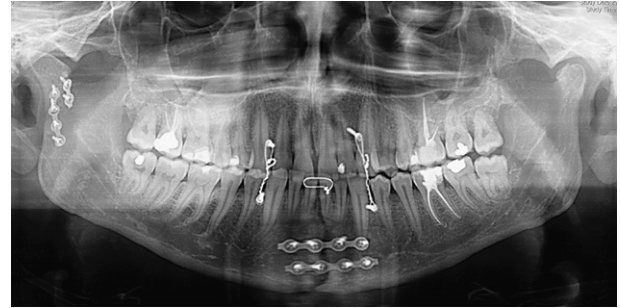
Postoperative orthopantomography (same patient).
